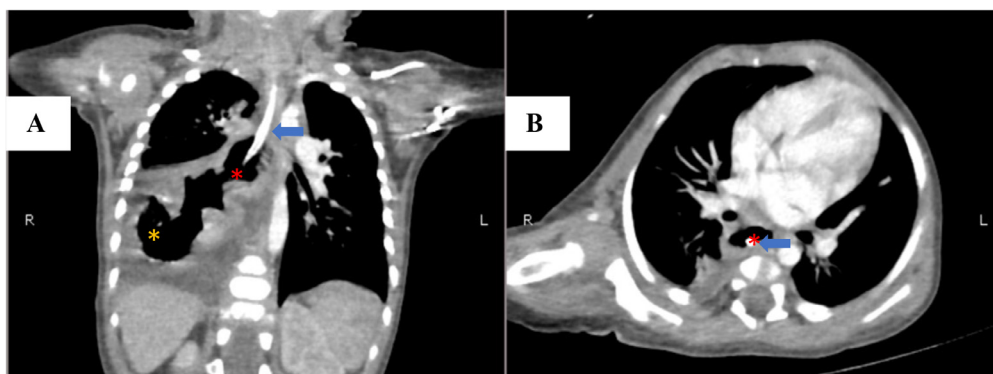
Coronal (A) and axial (B) mediastinal window chest CT show the nasogastric tube (blue arrow) in the oesophagus (red star) entering the stomach (yellow star), with widening of the gastrooesophageal junction.
